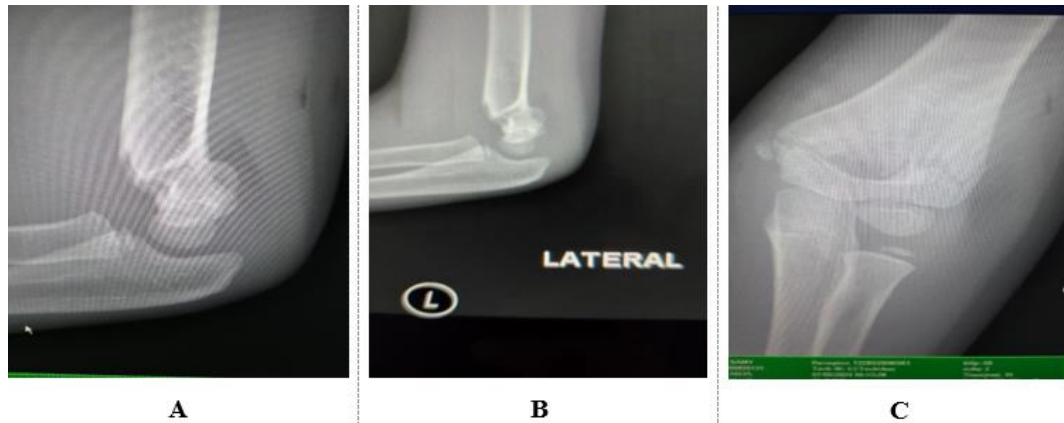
Initial Lateral and Anteroposterior Radiographs Demonstrating Gartland Type IIB Supracondylar Fracture of Humerus with Posterior Displacement and Intact Cortical Contact
